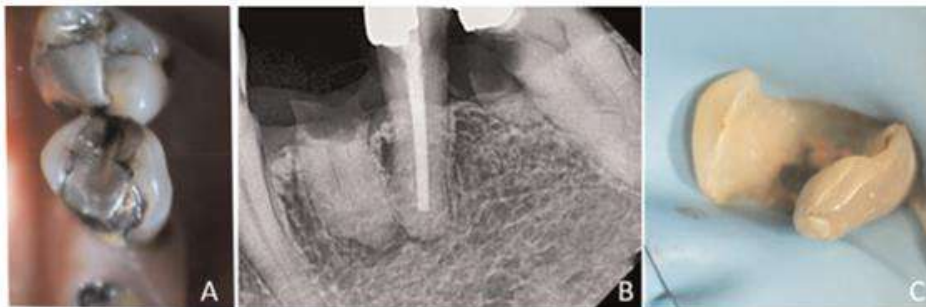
A. Preoperative clinical view of 36. B. Radiographic preoperative. C. Amalgam removal and access opening.
